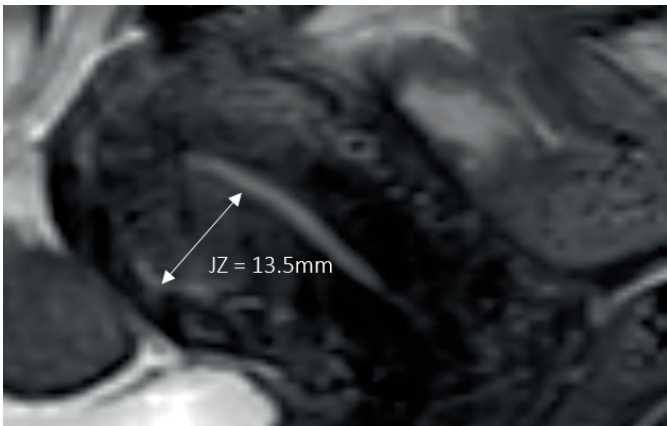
Sagittal T2W MRI showing the junctional zone (JZ) with a diameter of >12m
